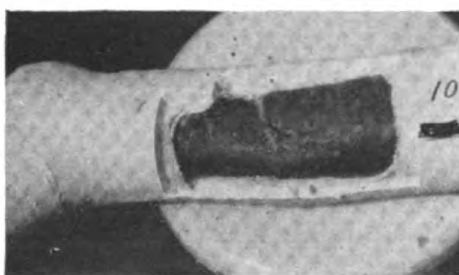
The viability of this bone graft has been preserved by raising a large contiguous pedicle flap in stages, medial to the wound. The flap was transposed to cover the defect. Donor area was covered with a split thickness skin graft. Roentgenogram shows the bone graft still viable and in the process of healing.
